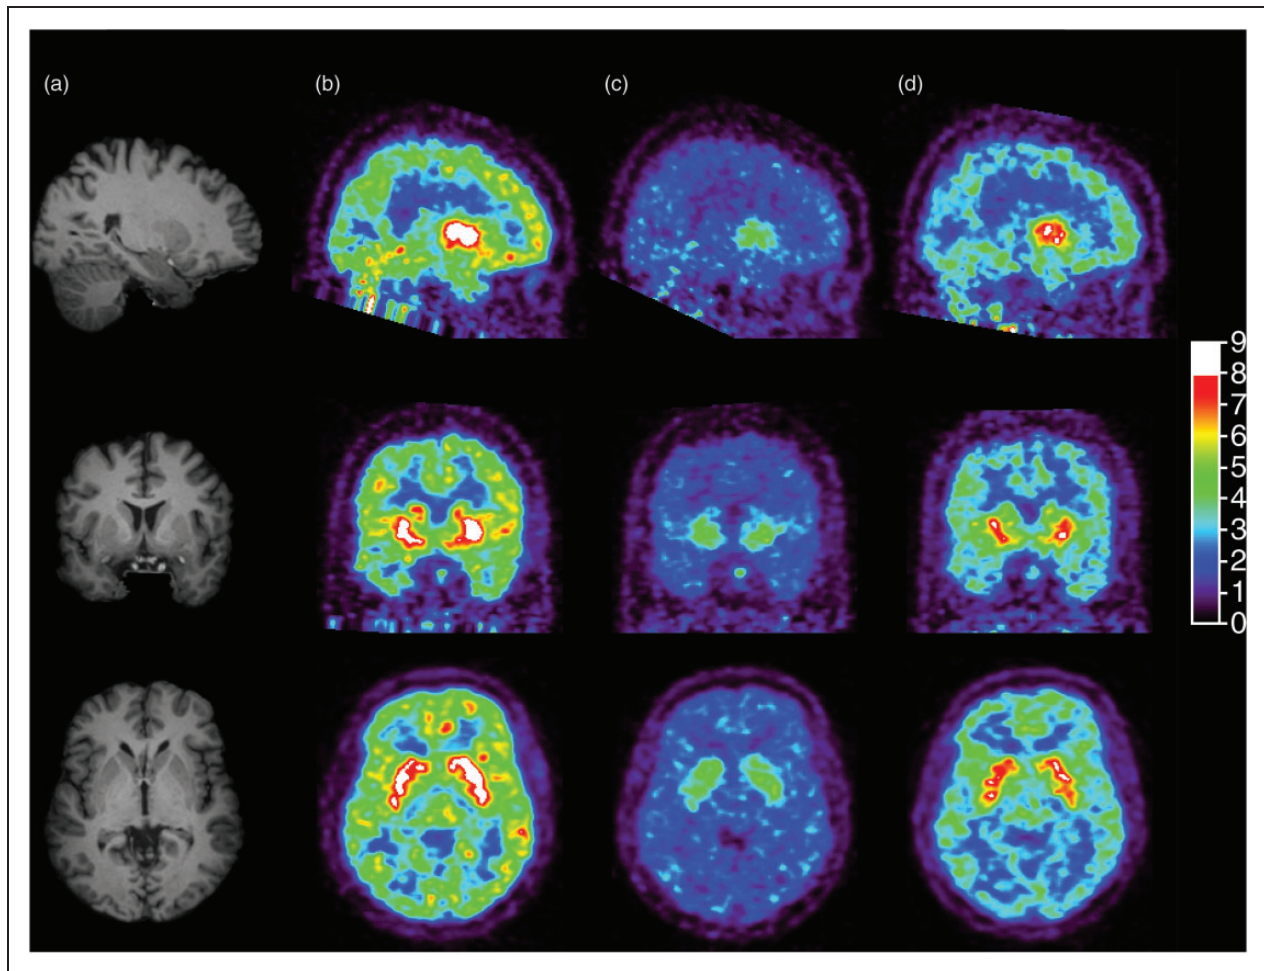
Sagittal (top), coronal (middle) and transverse (bottom) MR images (a) and brain images of [^{11}C]GSK189254 standard uptake value at 60–90 min post-injection during the baseline scan (b), the 3-h post-drug scan (c) and the 24-h post-drug scan (d) for a representative subject who received a dose of 0.5 mg of PF-03654746.
